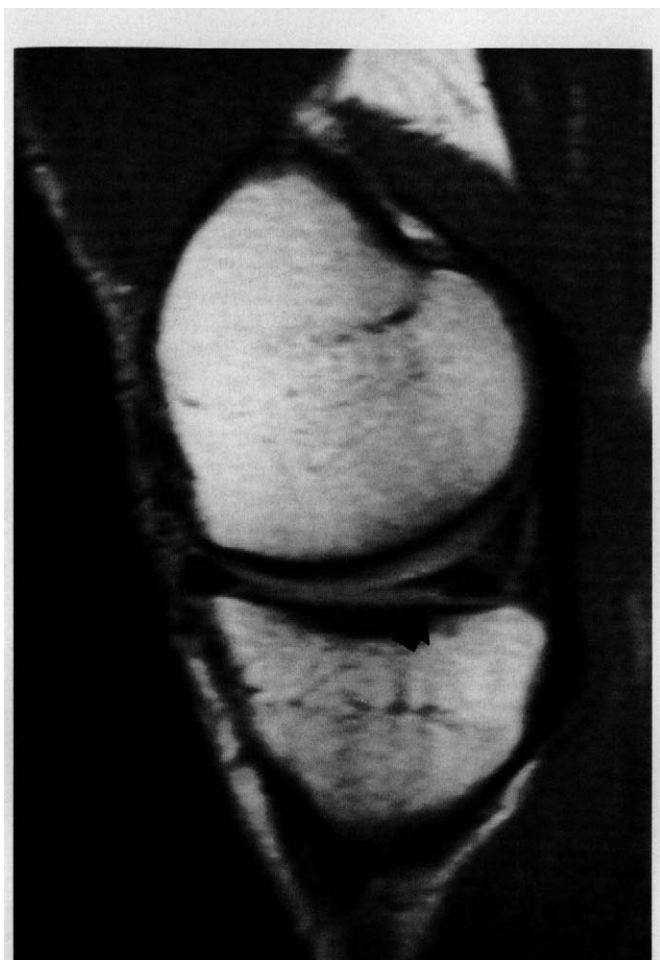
Sagittal section MRI scan demonstrating a posterior horn tear of the medial meniscus (arrow) in an asymptomatic 31-year-old man.
